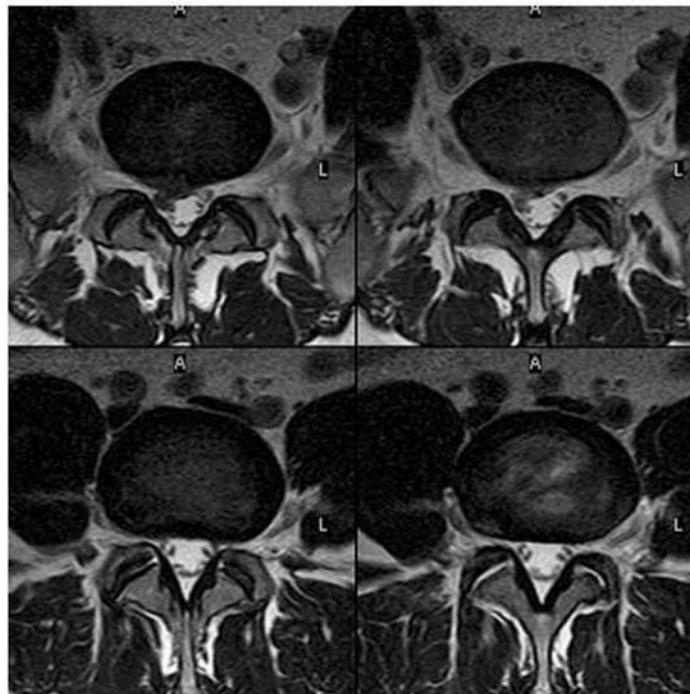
Axial/oblique FSE T2-weighted image of the lumbar spine (Westbrook, 2014)
